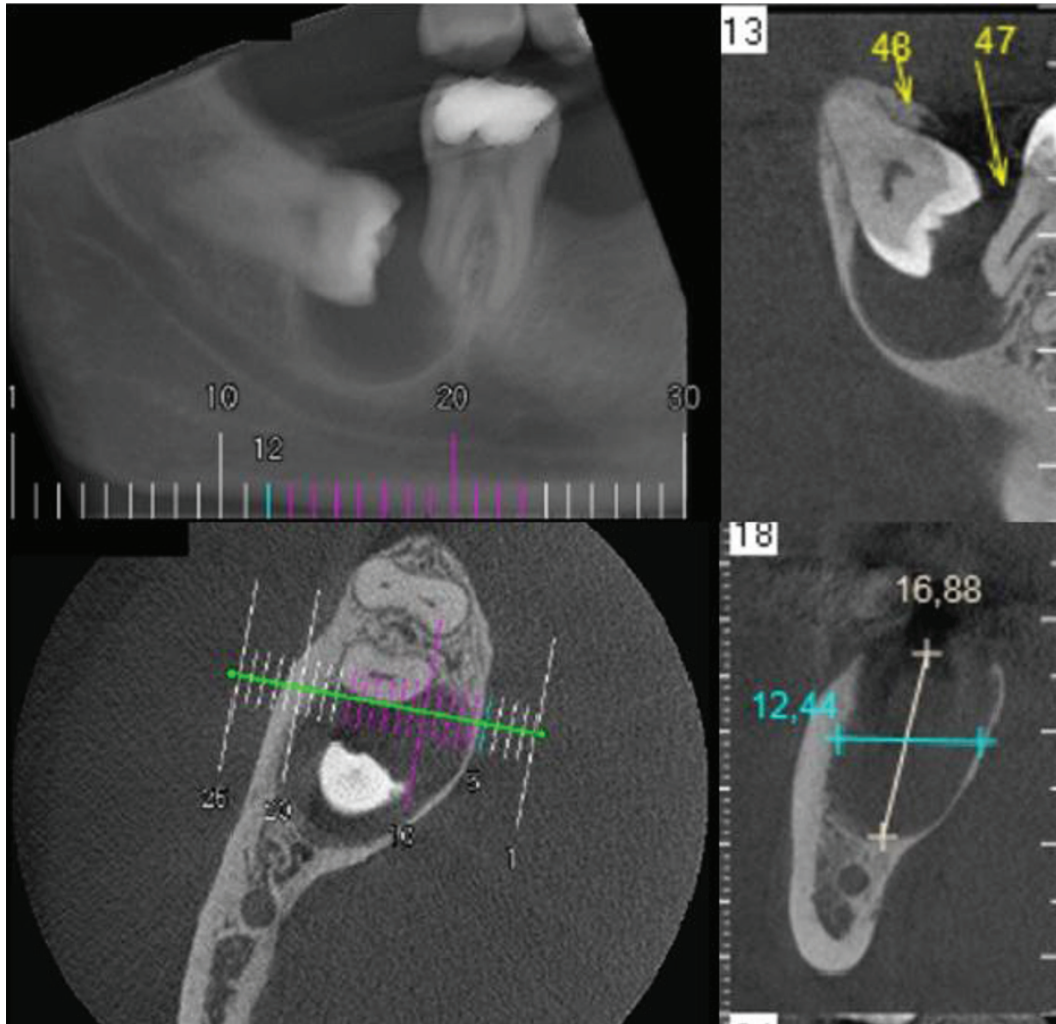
Preoperative CBCT showing well-defined unilocular radiolucency associated with an impacted right third molar extending to the distal root of the second molar.
